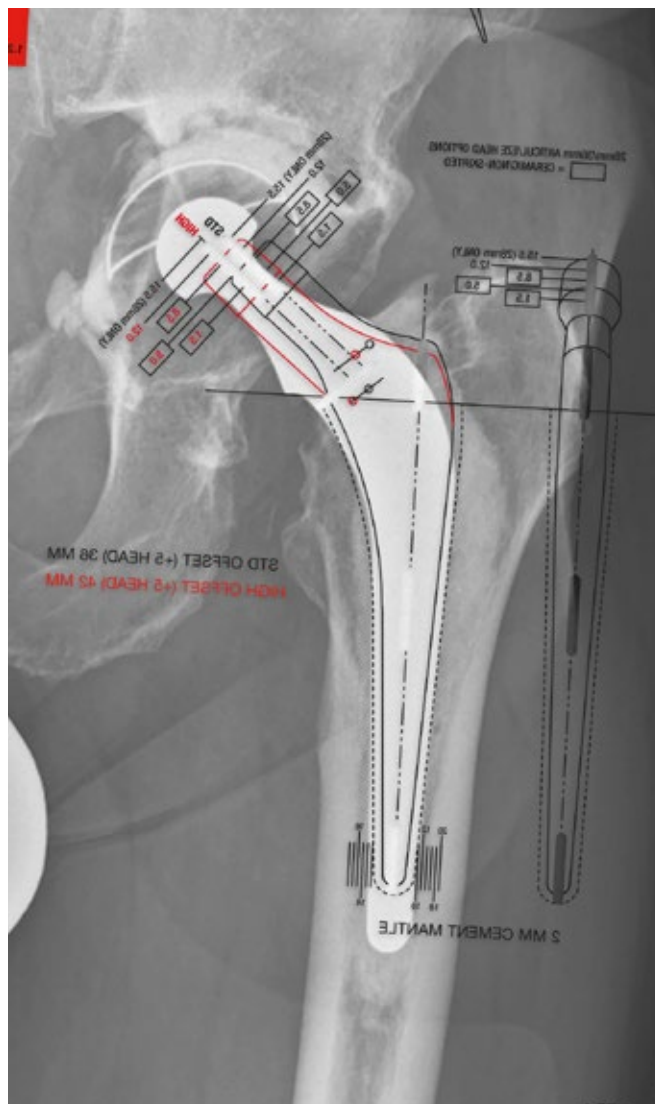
C-STEM AMT X-ray templating.
